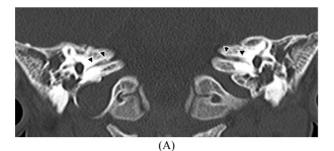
(A) Thin axial CT cuts bone window revealed bilateral hypoplastic internal auditory canals [arrow heads] more on the right side, measuring about 2.4 mm on the right and 3mm on the left. (B) Corresponding 3-D-coronal GR T2 WIs of the same patient confirms bilateral IAC hypoplasia.
